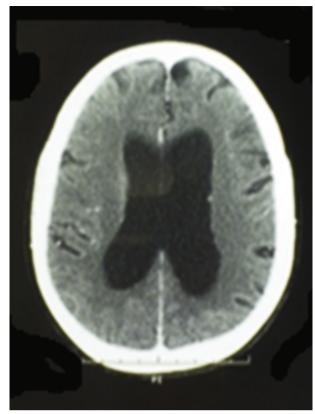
CT scan showing findings of chronic compensated hydrocephalus leading to normal pressure hydrocephalus.
